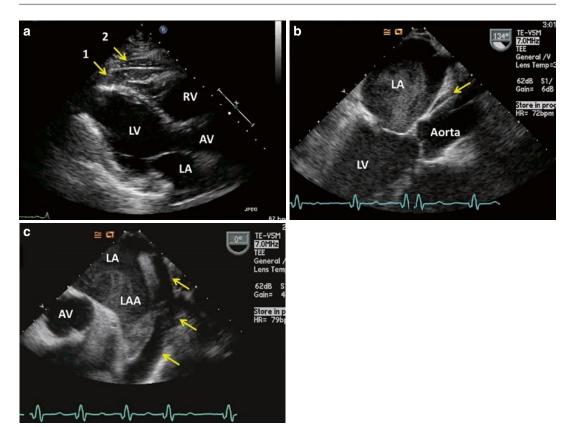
Pericardial anatomy. Panel a: Pericardial fat pad on transthoracic echocardiogram in the parasternal longaxis view. Note the heterogeneous appearance of the two layers of pericardial fat (*arrows*); one layer is intrapericardial (epicardial; #1), and the other is extrapericardial (mediastinal; #2). Panel b: Transesophageal echocardiogram demonstrates effusion in the transverse sinus (*arrow*) of the pericardium adjacent to the ascending
